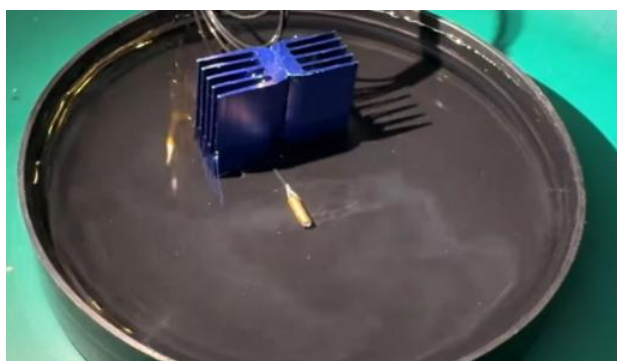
Water splashes generated by the ultrasonic ablation transducer during operation in water
